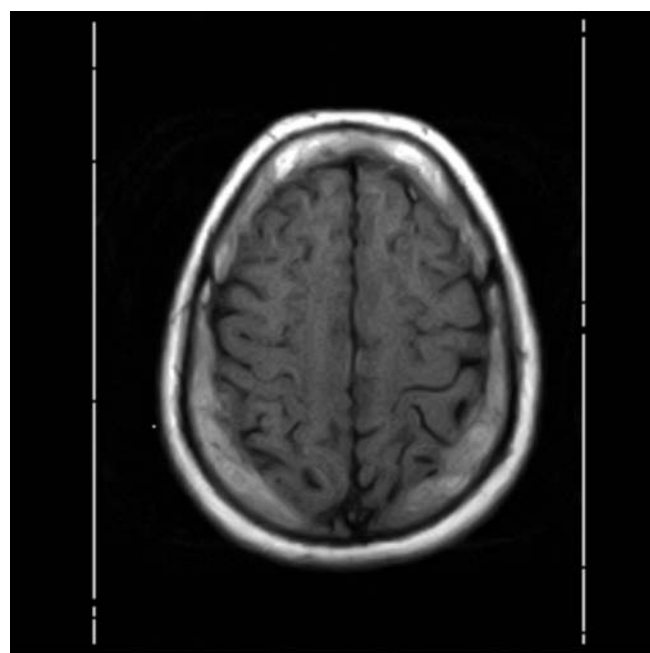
Axial T1-weighted MRI shows compression of underlying parenchyma due to HFI
